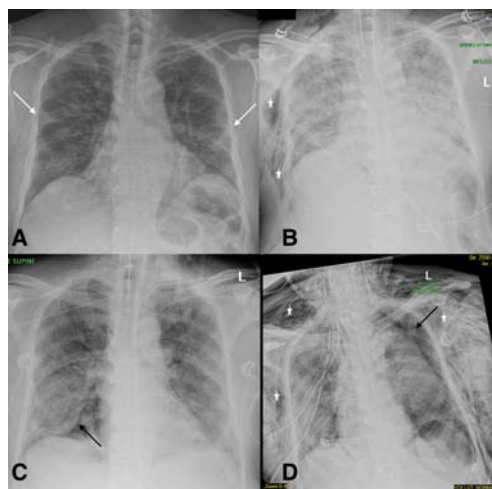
Serial CXR's of a patient with COVID-19 showing development of atypical findings during the admission. The admission radiograph (A) demonstrates multifocal peripheral opacities (white arrow), followed by the development of right pneumothorax (black arrow) on day 7 (B) of admission with improvement in parenchymal changes subsequently on day 15 of admission (C). He developed extensive left pneumothorax (black arrow) and surgical emphysema (star)(D) of the chest wall later in the course. Images courtesy of Dr Amrita Bajaj, Glenfield Hospital, Leicester.
